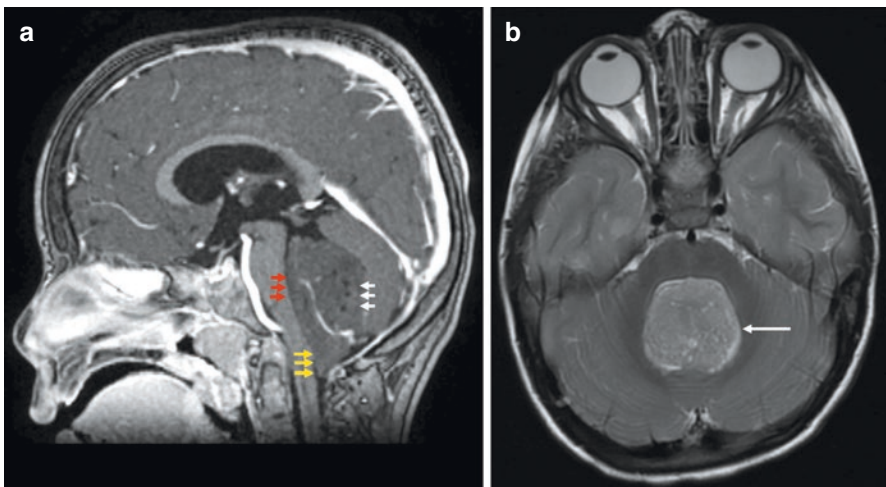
MR images of a patient with medulloblastoma including (a) T1-weighted sagittal MRI brain with contrast and (b) T2-weighted axial MRI brain. Images demonstrate a well-defined, rounded mass in the posterior fossa, within the fourth ventricle (b, arrow). The mass extends through the foramen of Magendie into the cervical region and through the foramen of Luschka, bilaterally (a, white arrows). The signal intensity is low on T2, intermediate on T1 with restriction to diffusion. There is mass effect upon the brainstem (a, red arrows) and extension into the craniocervical junction (a, yellow arrows)
